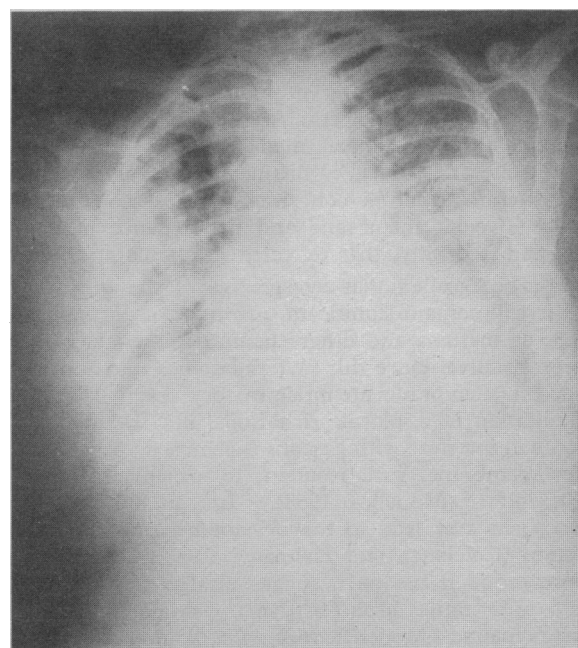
Case 3. Chest x-ray appearances 20 hours after admission.
